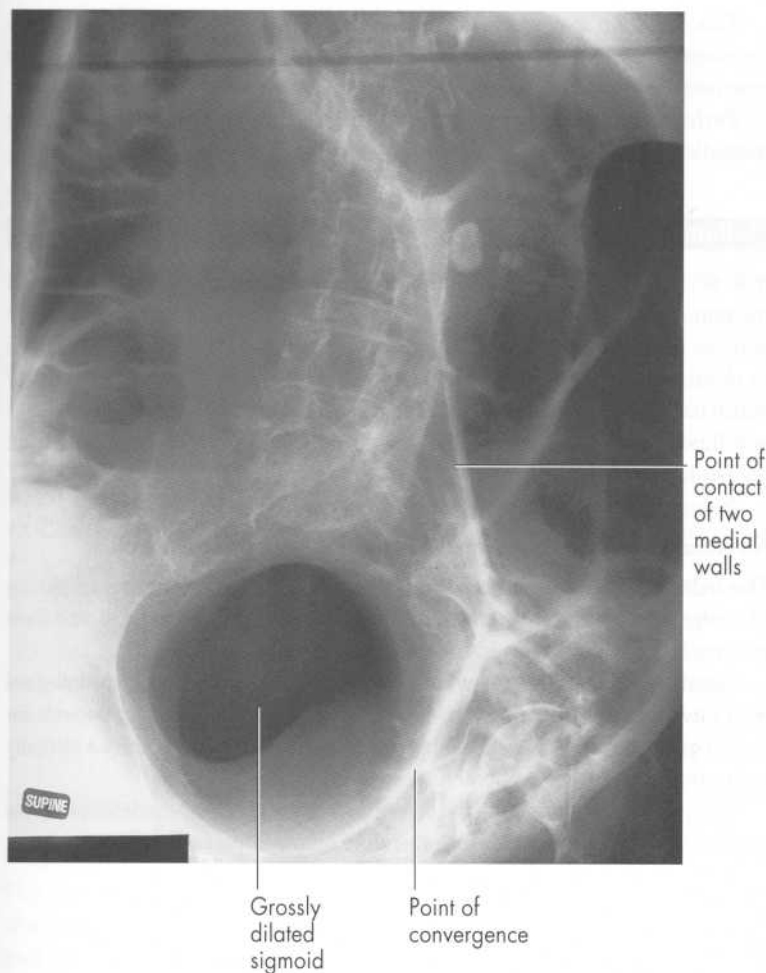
Supine AP radiograph. Sigmoid volvulus. An elderly institutionalized woman aged 76 with an acute exacerbation of long-standing intermittent abdominal symptoms of pain and distension, and prior constipation. Note the distended sigmoid. This is the famous 'coffee bean' sign.
